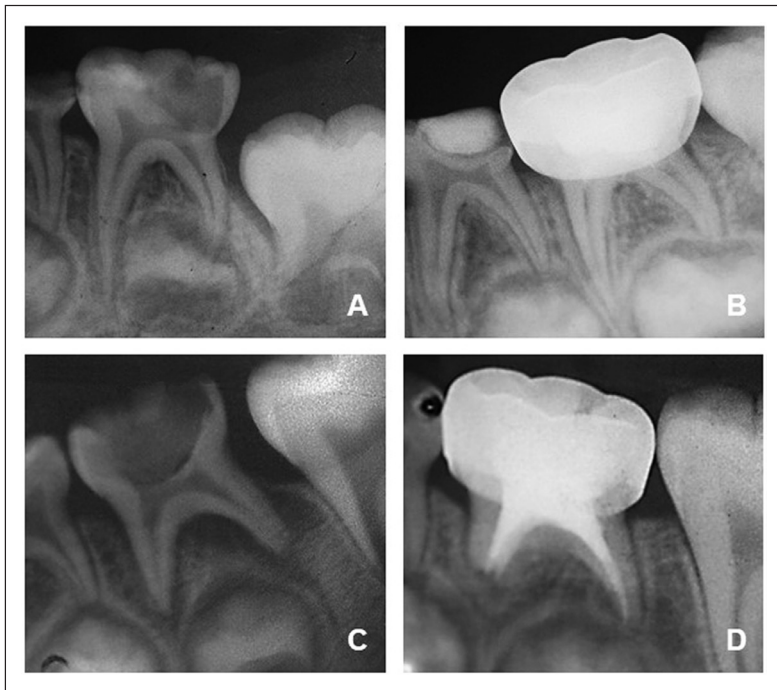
CTZ and ZOE folder: initial conditions and 12 months controls. CTZ paste: (A) initial condition (B) radiographic evaluation 12 months. ZOE Paste: (C) Initial condition; (D) Radiographic evaluation 12 months.
